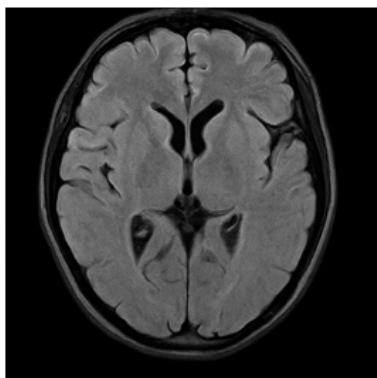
Undergone of MRI, which revealed normal.
